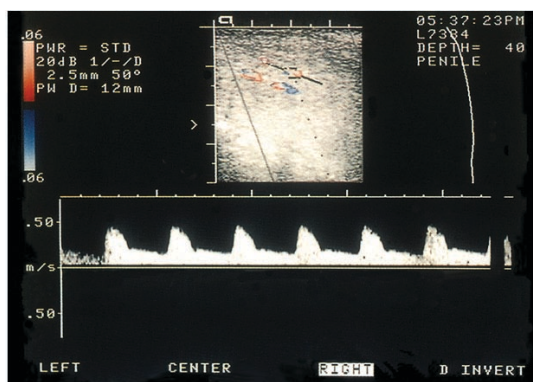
Penile duplex ultrasound.
